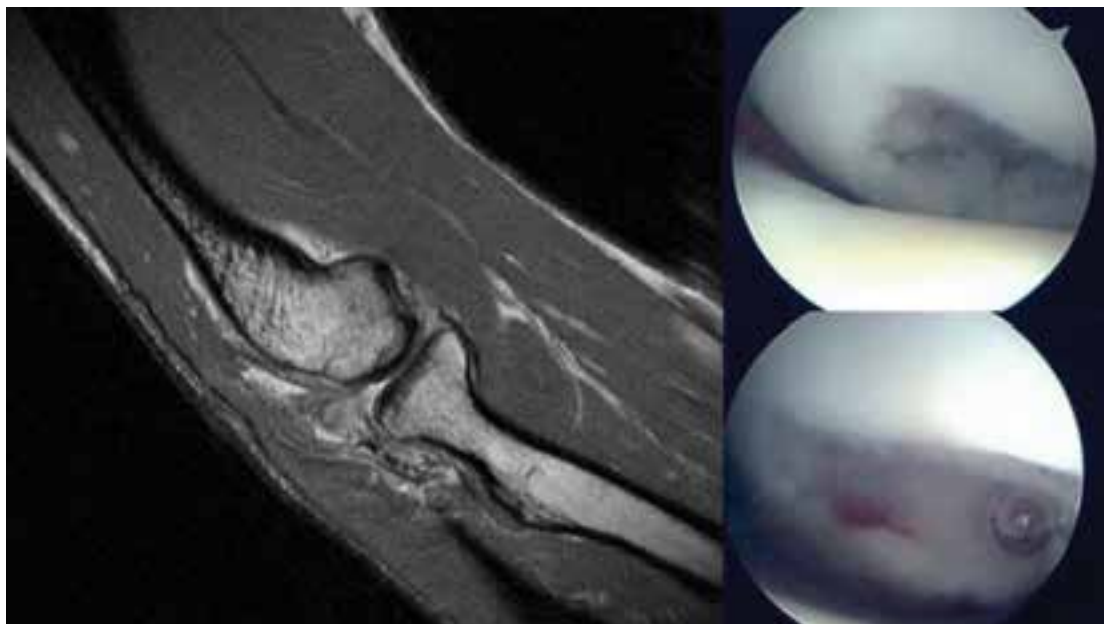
The MRI and intraoperative findings associated with osteochondritis dissecans of the capitellum (before and after surgical debridement).
